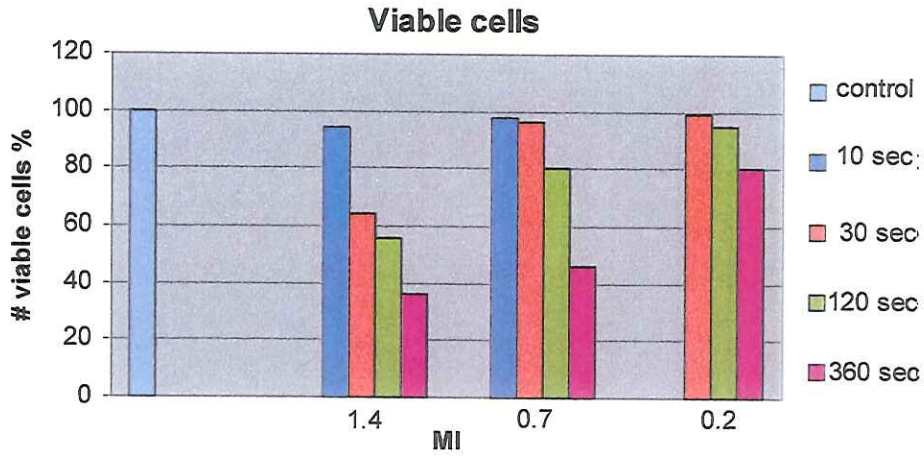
Viable cells. GFP transfected CHO cells exposed to ultrasound during various exposure times (seconds) at various MI's. Relative number of cells surviving compared to the control (=100%)
